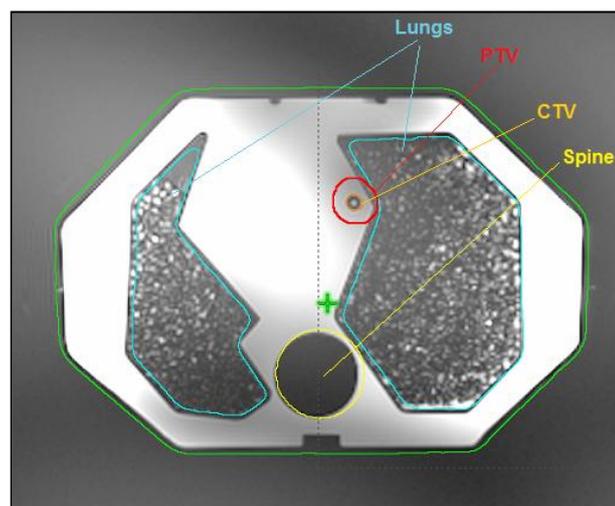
Axial MRI volumes.
